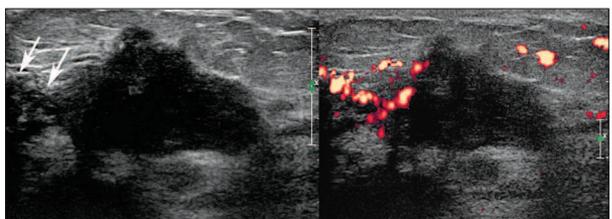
Images from a 36-year-old woman with pain and a palpable mass in her right breast. Left, Sonogram showing an irregularly shaped hypoechoic mass that was poorly defined in some areas and extended into the periareolar ducts (arrows). Right, Surrounding tissue showed increased echogenicity due to edema with hypervascularity. Pathologic findings after a core needle biopsy confirmed acute inflammation.
